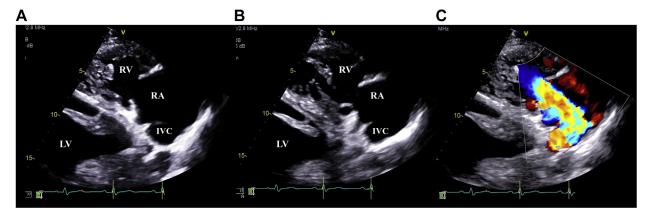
Two-dimensional TTE oriented in a right ventricular inflow view showing a thickened and fixed, semiopen tricuspid valve with minimal change between end systole (A) and end diastole (B). Color Doppler revealed severe TR due to the leaflets being fixed in a semiopen position (C).
